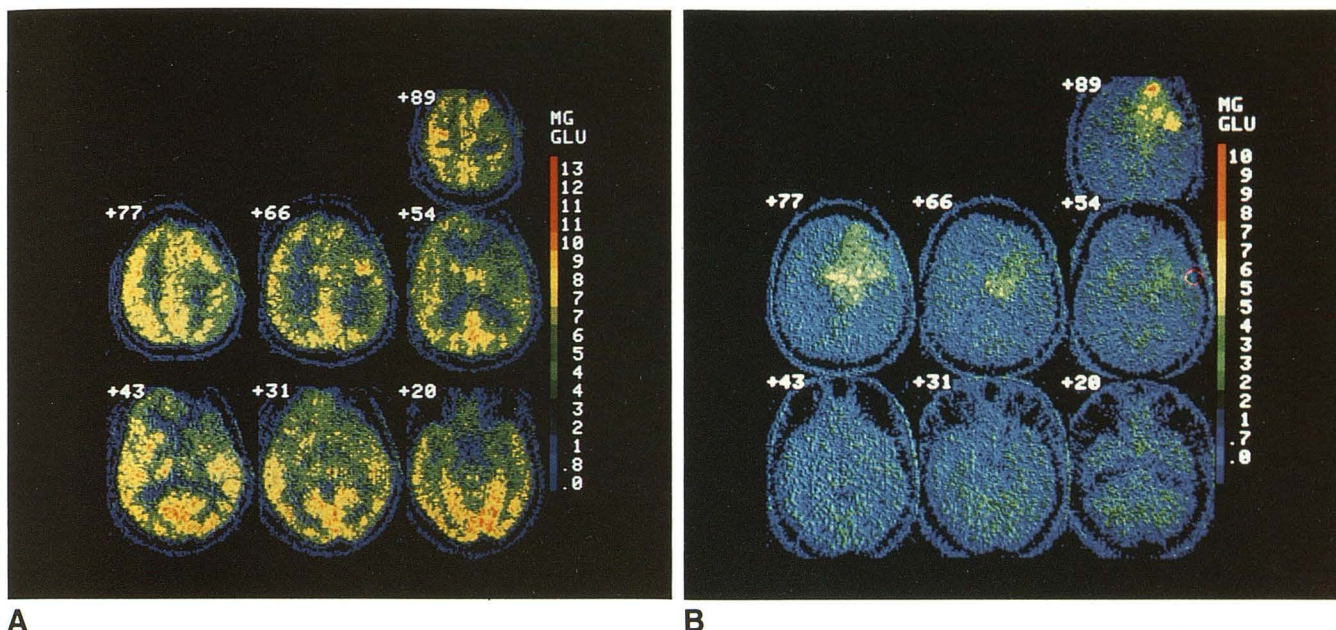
PET-FDG studies of a cortical and deep-seated high-grade glioma.
